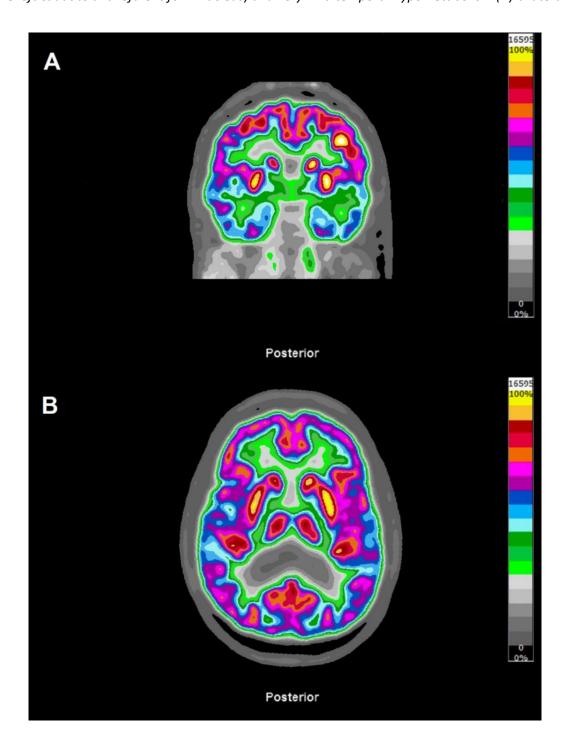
FDG-PET-CT [(A) coronal, (B) axial] showing hypermetabolism (A, B) in the left basal ganglia (increased tracer uptake in the left caudate and left lentiform nucleus) and very mild temporal hypometabolism (A) bilaterally.
